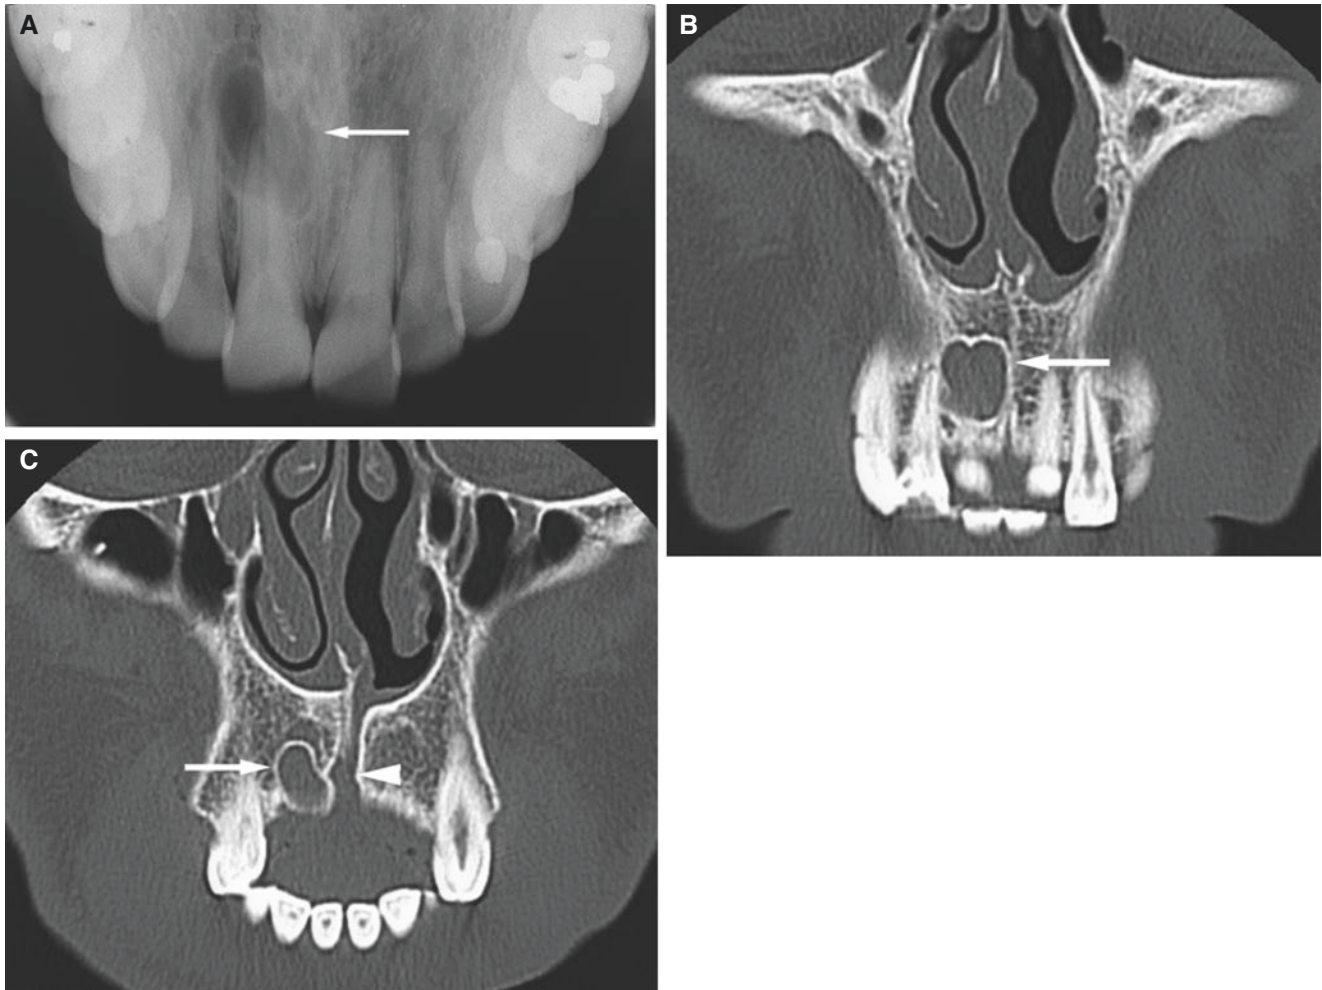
Lateral periodontal cyst, maxilla; 35-year-old male with incidental finding at routine dental radiography; vital teeth. (A) Intraoral view shows oval periapical radiolucency with sclerotic border (*arrow*) and normal apical periodontal ligament of teeth. (B) Coronal CT image
